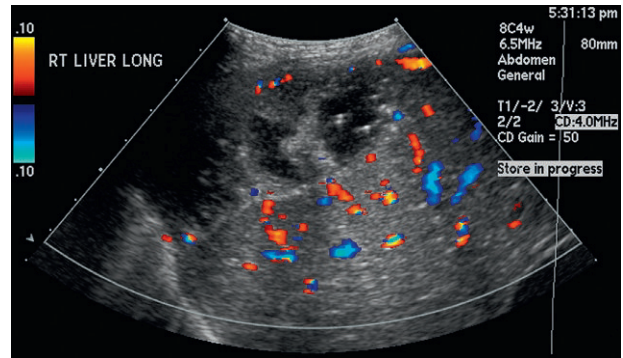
Color Doppler ultrasound demonstrates little color within the complex mass.
